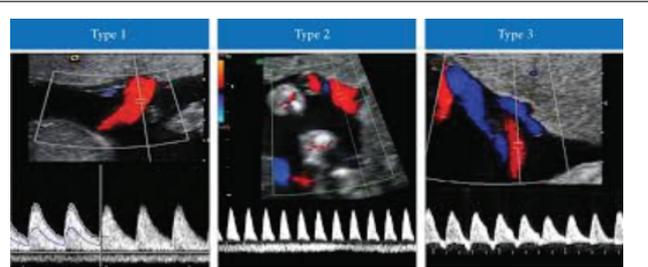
Doppler ultrasound showing multiple pregnancy.
